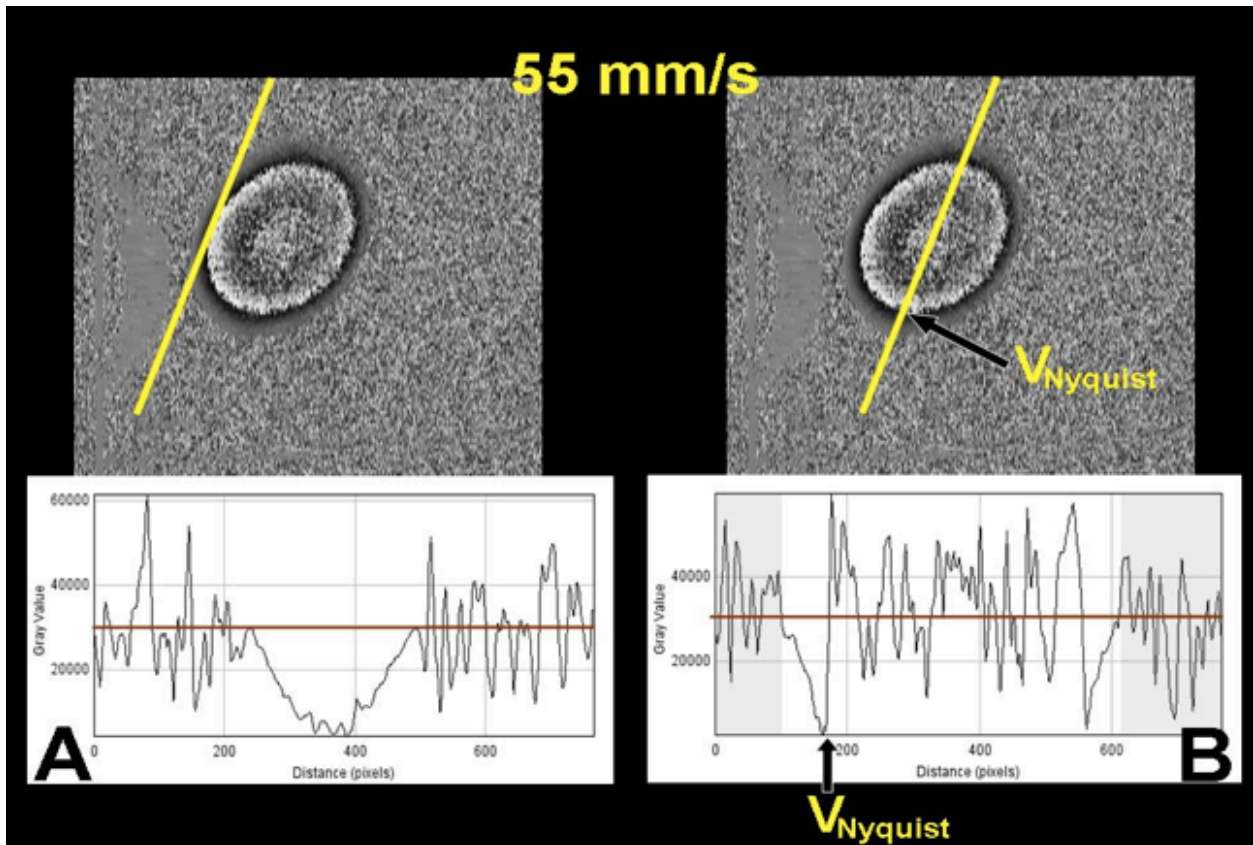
Doppler shift and velocity profile maps.
